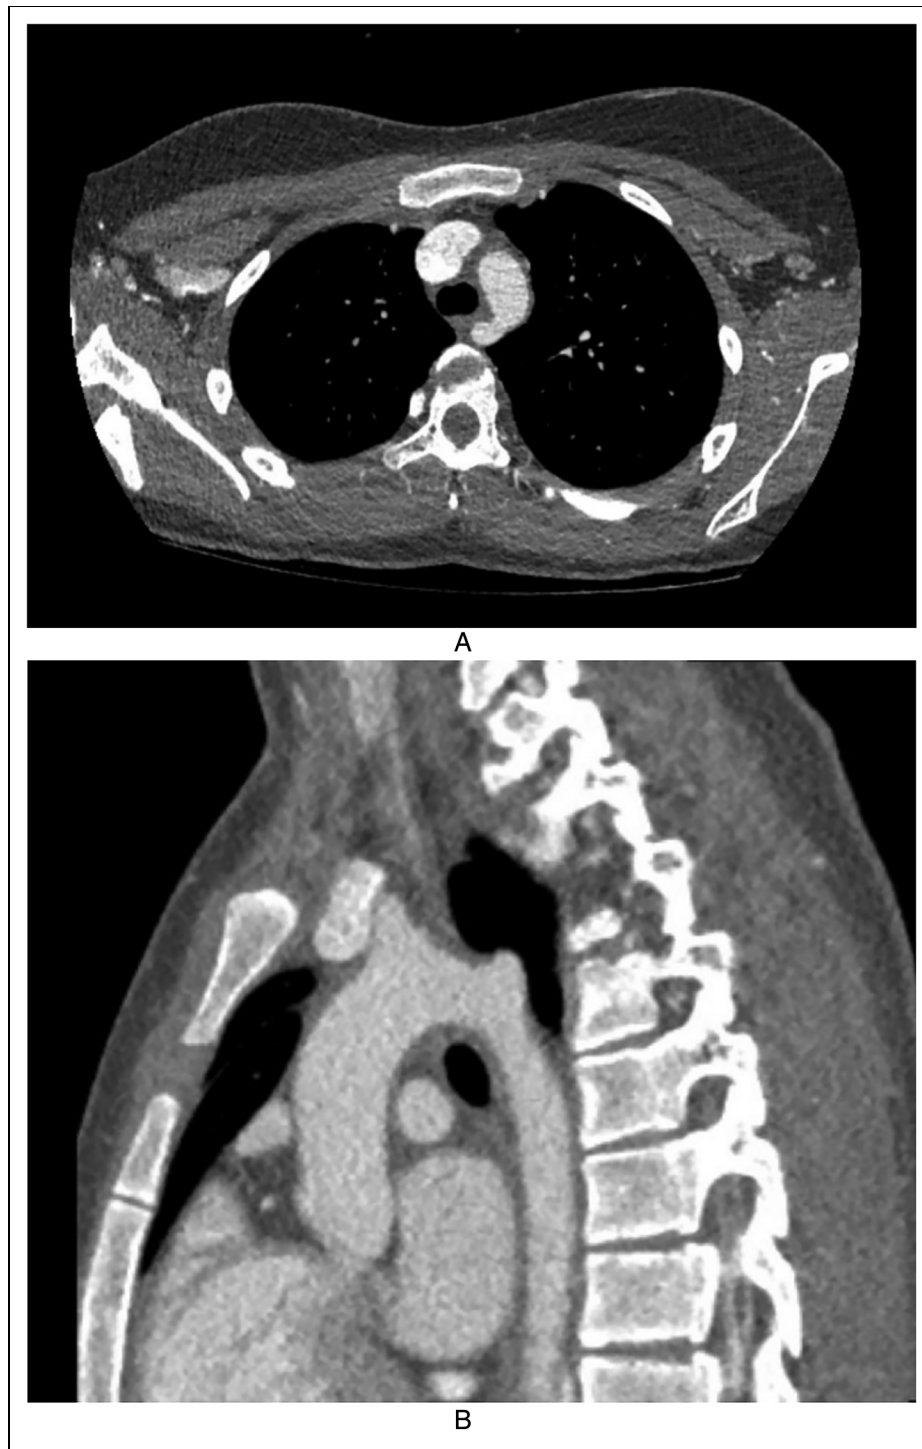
A and B, Computed tomography scan of the chest in axial (left) and sagittal (right) views demonstrating the right subclavian artery emerging from the left aortic arch coursing posteriorly behind the esophagus without a Kommerell diverticulum (left).
